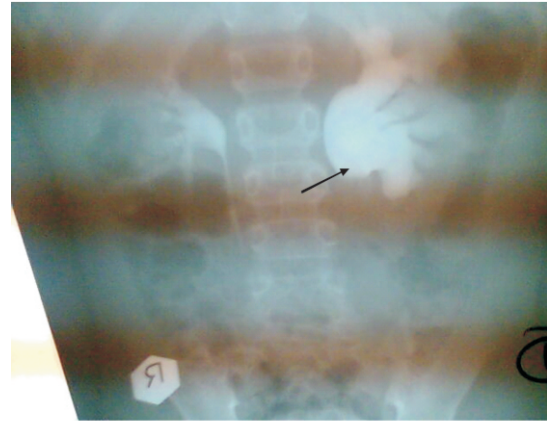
The Pyelography one year later showing bilaterally enlarged kidneys, worse on the left, with persistent nephrogram in the 2-hour delayed radiograph.
